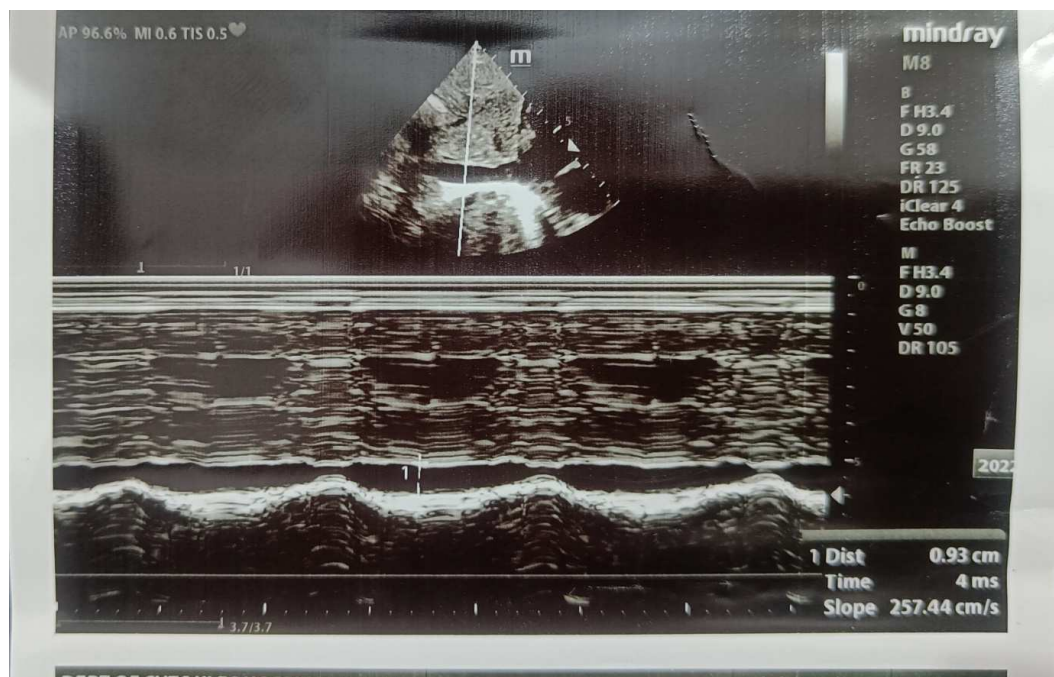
bedside echocardiography showing change in inferior vena cava diameter with respiration, (0.93 cm) which along with other clinical data showed that fluid resuscitation should be maintained. Neither there is fluid overload nor IVC collapse.
